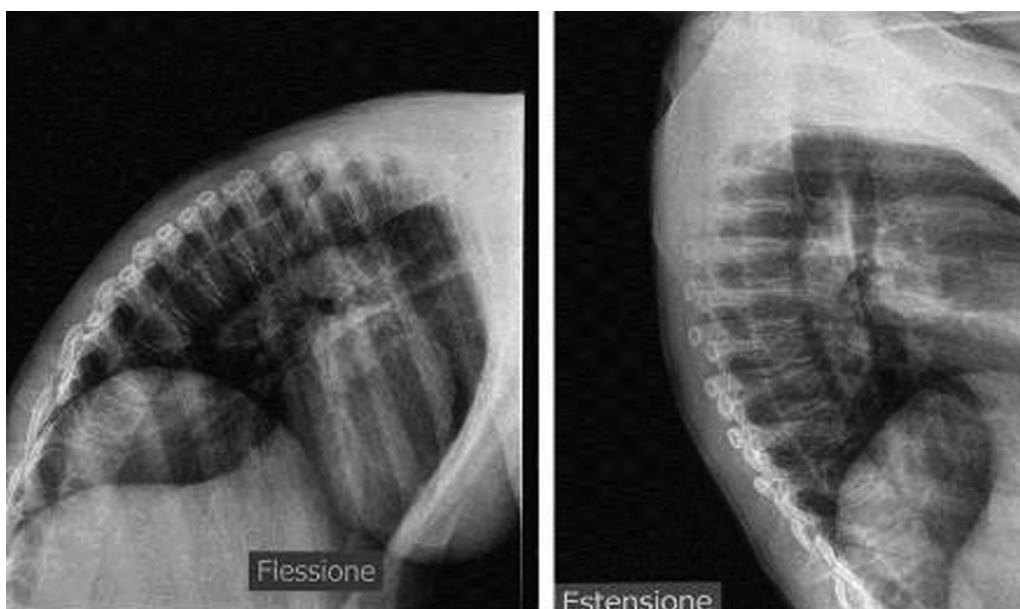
Dynamic (Right Flexion–Flessione Left Extension–Estensione) Thoracic spine X-ray exam excluding postoperative instability.
